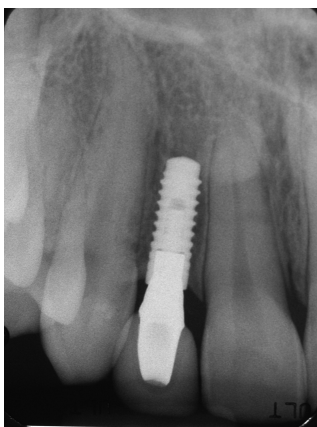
26-month-postoperative radiograph with stable bone levels and a stable implant/abutment connection
